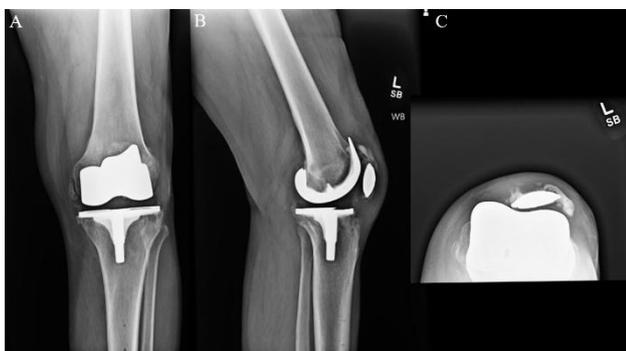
(A) AP, (B) lateral, and (C) sunrise radiographs nine months post-operatively after patelloplasty.
